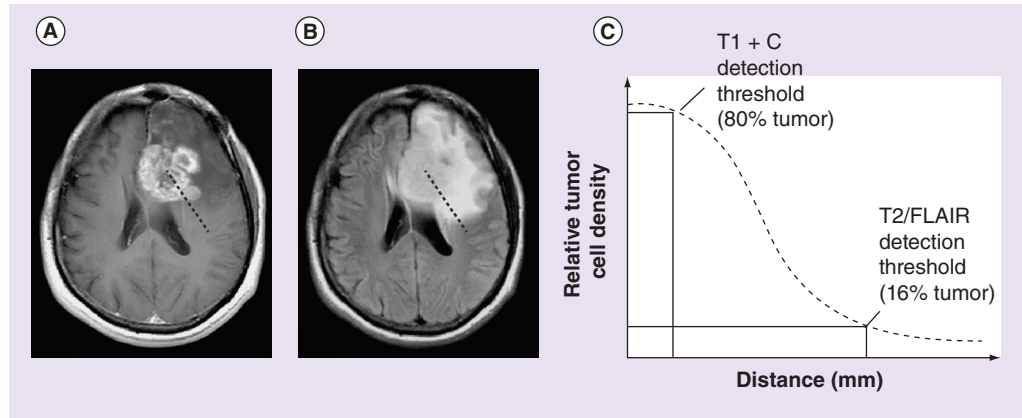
Estimation of relative tumor cell density for use in the mathematical model using anatomic MRI scans. A line drawn from the center of the tumor toward the periphery on (A) contrast-enhancing tumor on postcontrast T1-weighted images and (B) T2 hyperintense regions on T2-weighted or FLAIR images depicts areas of high and low cell density, respectively. As shown in (C), the edge of the contrast-enhancing tumor is used to describe the isocellularity line at 80% of the tissue carrying capacity while the edge of the T2 hyperintense lesion describes the isocellularity line at 16% of the tissue carrying capacity. These measurements are used to estimate the gradient of cell density across the brain.
